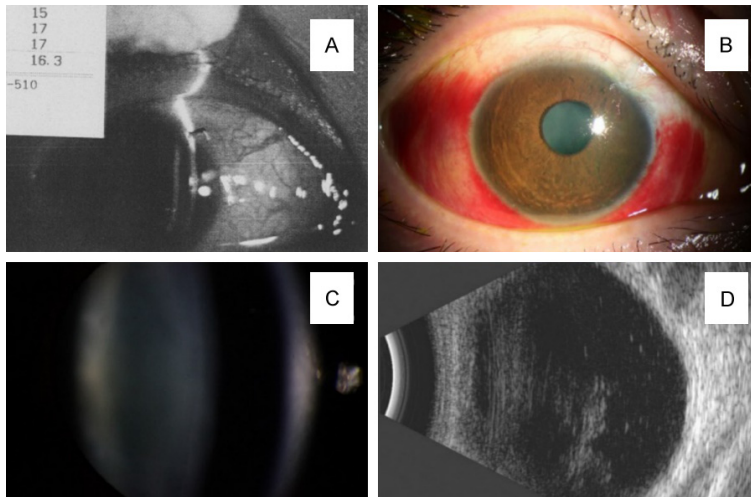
A. Slit lamp examination of the right eye of the patient in the local hospital. Image shows conjunctival congestion and penetrating wound. B. Slit lamp examination of the right eye of the patient in our hospital. Image shows conjunctival congestion and penetrating wound scarring. C. Slit lamp examination of the right eye of the patient in our hospital. Image shows early stage of cataract. D. Ultrasound image of the right eye of the patient in our hospital shows a rough particle in the vitreous cavity without the signs of endophthalmitis.
